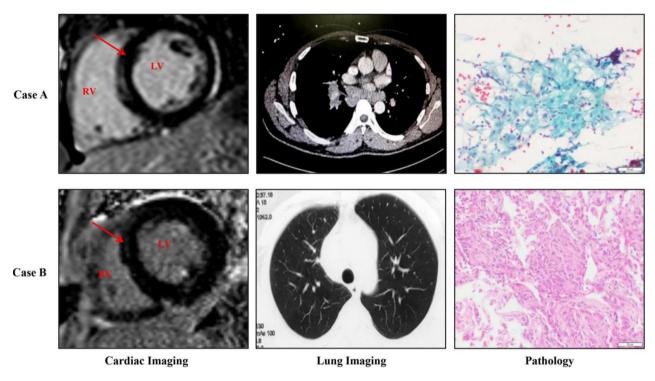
Case A was a 38-year male having shortness of breath, palpitations with VT. The cardiac MRI showed LGE. Chest CT showed mediastinal lymphadenopathy but no parenchymal involvement. Non-necrotizing Granulomas were demonstrated in the EBUS-TBNA sample. Case B was a 49 years old male having shortness of breath and fatigue, with an ejection fraction of 45% on echocardiography. The cardiac MRI showed LGE. Chest CT showed bilateral lung nodules. Non -necrotizing granuloma was demonstrated in the TBLB sample. (MRI Magnetic resonance imaging, LGE Late gadolinium enhancement, VT Ventricular tachycardia, CT Computed tomography, EBUS Endobronchial ultrasound, TBLB Transbronchial lung biopsy).
